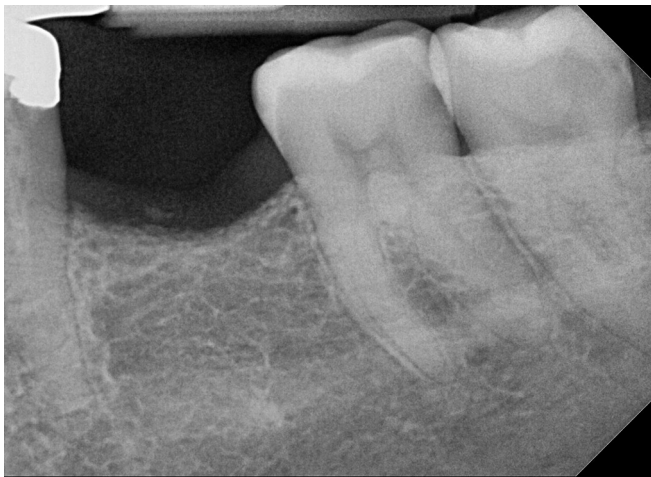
Preoperative periapical X-ray demonstrating the need for implant restoration at a single-tooth site. The mandibular first molar was extracted 9 months prior.
